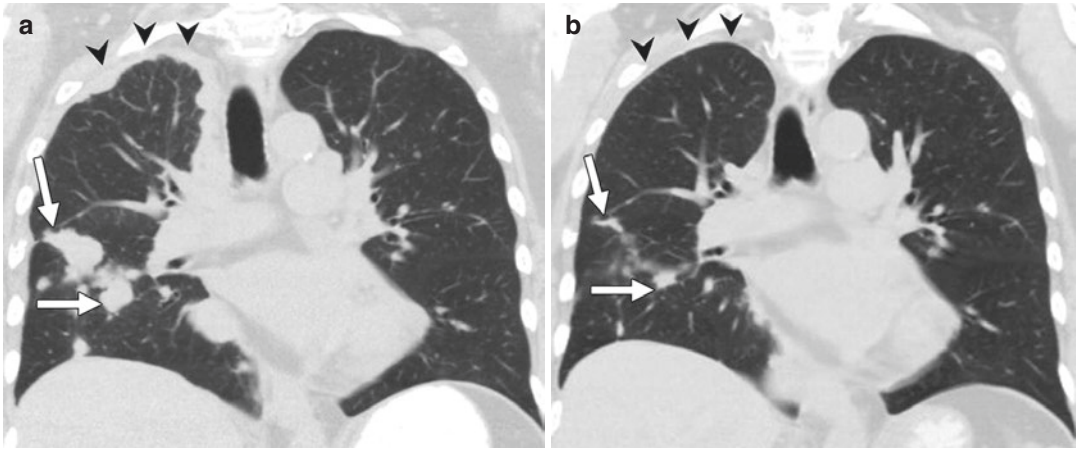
Images in a 70-year-old woman with stage IV adenocarcinoma harboring ALK (anaplastic lymphoma kinase) translocation treated with ALK inhibitor, crizotinib. (a) Coronal reformatted image from baseline chest CT demonstrates multiple nodules in the right lung (arrows) with nodular thickening of the right apical pleura (arrowheads), representing significant tumor burden. (b)
